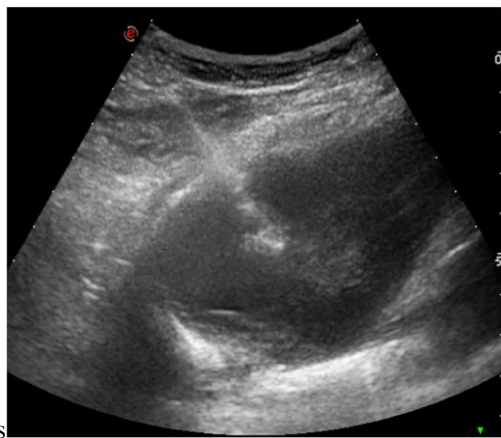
Ultrasound-guided FNB biopsy of a pulmonary nodule in the left lower lobe
